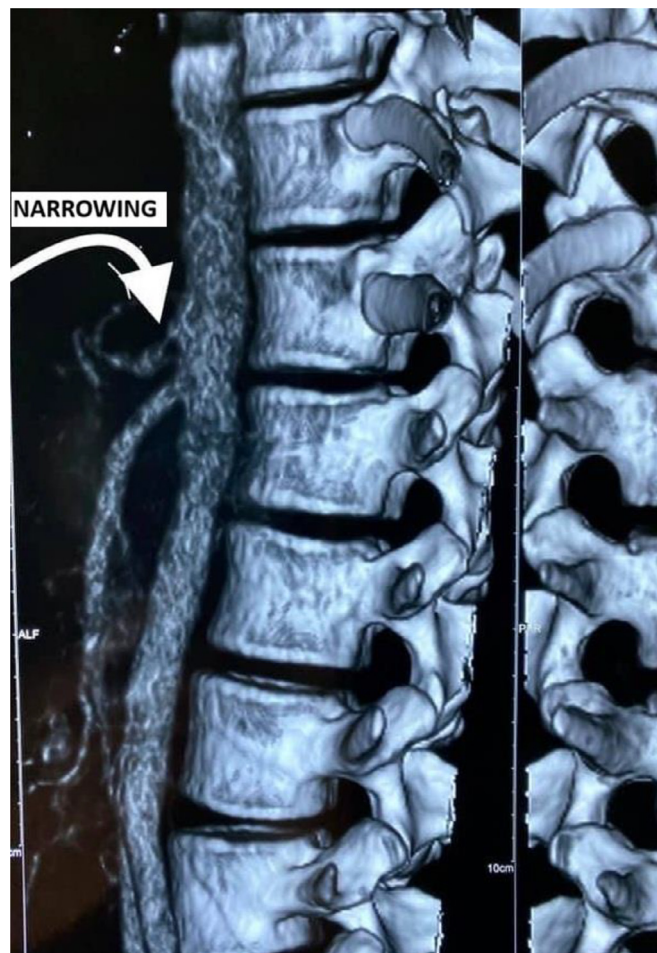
Preoperative CT angiogram showing median arcuate ligament compressing the celiac artery and its narrowing immediately after the origin.
